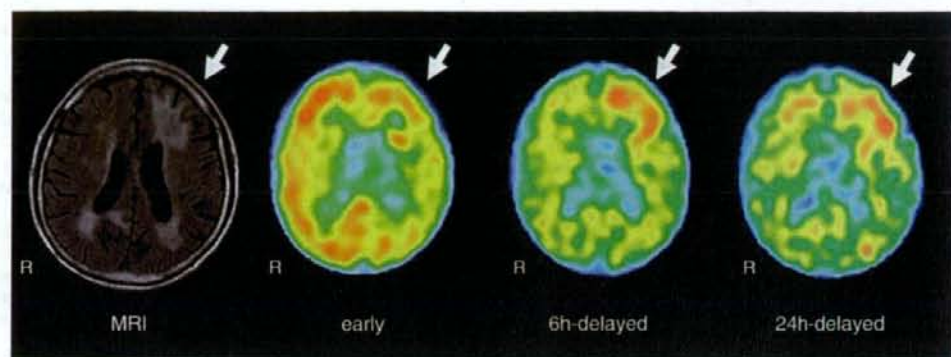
Axial FLAIR MRI and Serial images of  $^{123}\text{I}$ -IMP SPECT: early image, 6-hour delayed image and 24-hour delayed image. These serial images shows a delayed increase of radioactivity, a gradual increase and long term retention of the tracer on the left frontal white matter.
